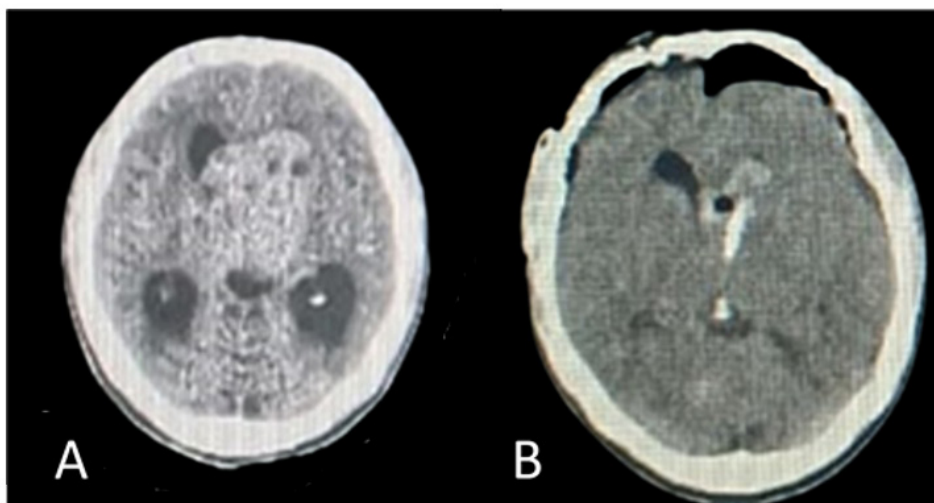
(A): Pre-operative CT brain showing intraventricular lesion at left frontal horn of the lateral ventricle and (B): Post-operative CT scans showing evacuated contralateral extra dural hematoma and inserted left frontal external ventricular drain.
